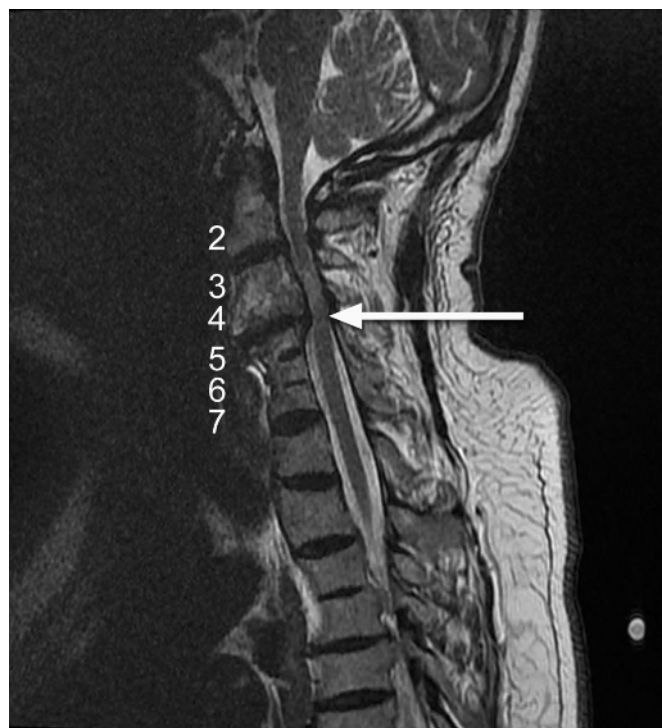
T2 MRI of sagittal cervical spine showing congenital synostosis of the C3/C4 and C5/C6/C7 vertebrae consistent with Klippel-Feil syndrome. The C3/4 disc-osteophyte complex is causing severe compression to the cord (arrow) and myelomalacia above this level. The relevant vertebral bodies are numbered.
